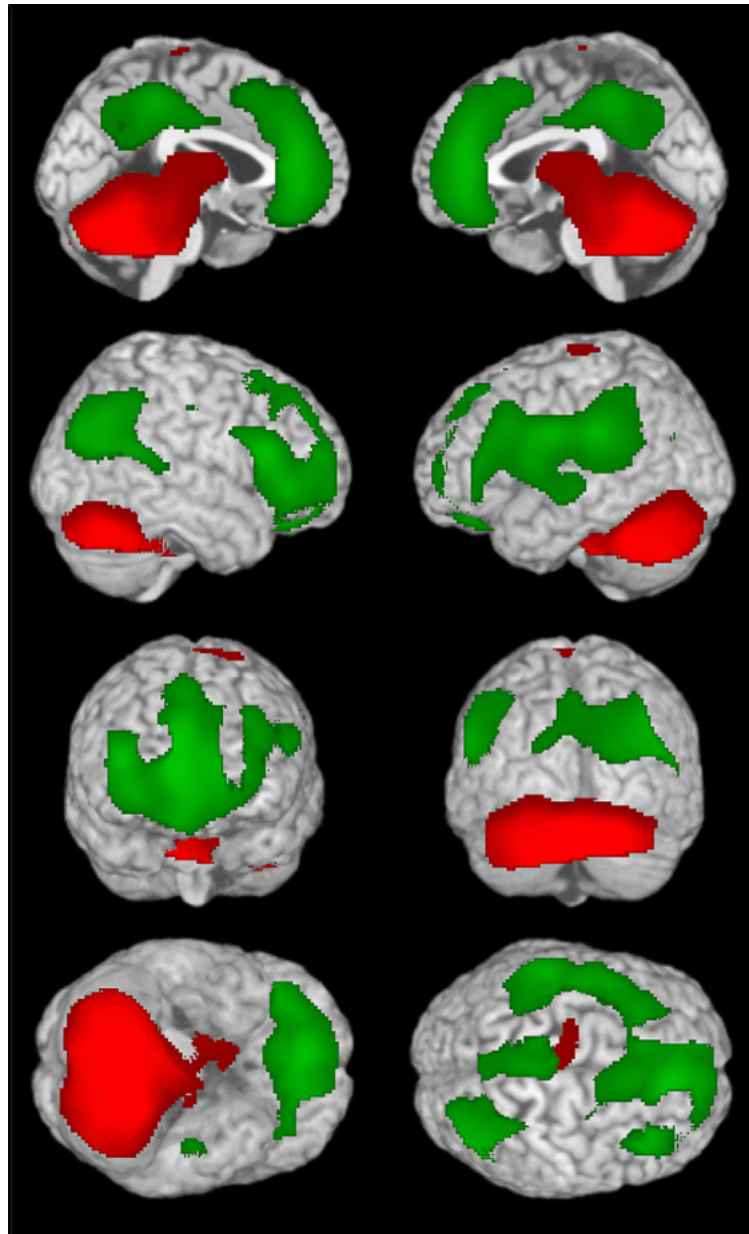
SPECT Imaging representations depicting hemispheric and cerebellar changes in blood flow distribution during and following generalized tonic-clonic seizures. Increases (red) in blood flow in cerebellar and thalamic regions correlate with decreased (green) flow in bilateral frontoparietal regions. Cumulative data obtained during 59 seizures in 53 subjects. (from: Blumenfeld H, Varghese G, Purcaro MJ, et al. Cortical and subcortical networks in human secondarily generalized tonicclonic seizures. *Brain* 2009;132:999–1012)
